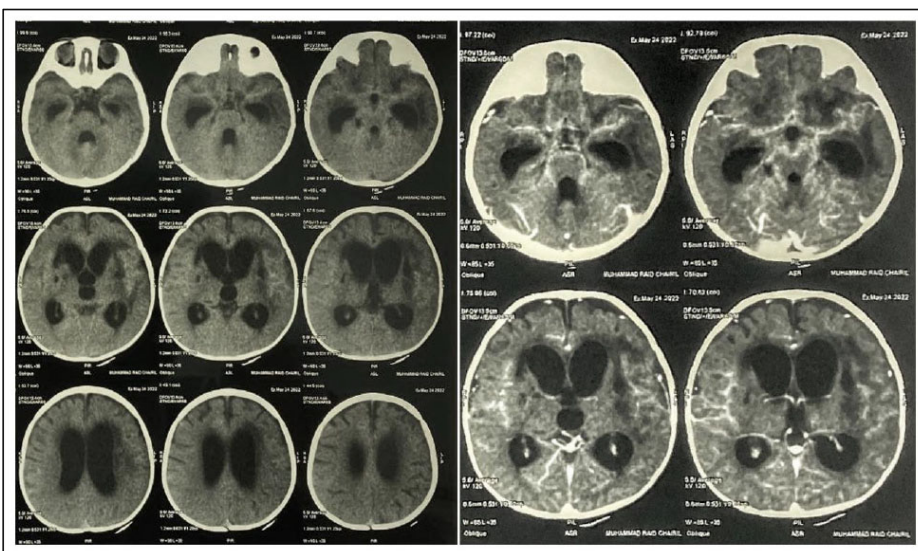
Head computed tomography scan in the axial section showed communicating hydrocephalus, pre-contrast basal hyperdensity, and bilateral infarction in basal ganglia and internal capsule (left). The head computed tomography scan with contrast in the axial section showed basal meningeal enhancement (right).
